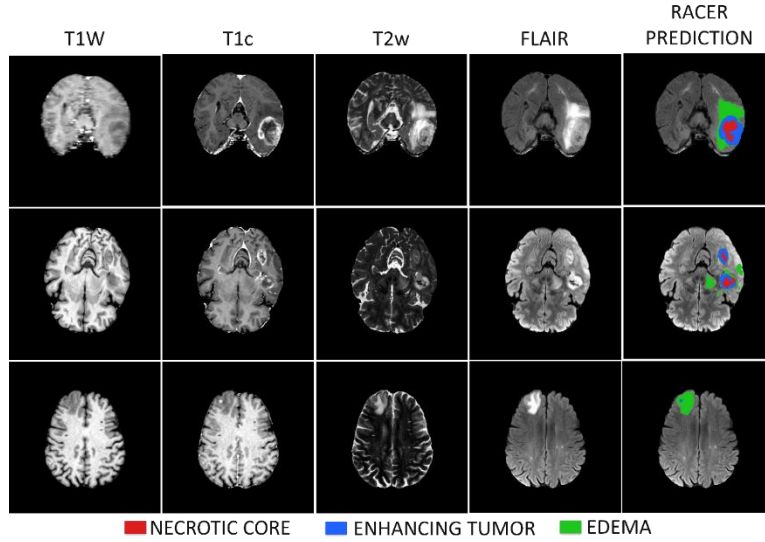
Validation cases, for which no reference is available, showing the four MRI channels and the RACER prediction overlaid on FLAIR.
